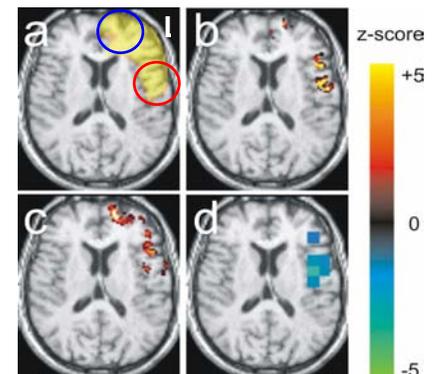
a) left frontal lobe mask (yellow) and pathological regions therein obtained from the b) ADC c) T2, and d) NAA/(Cr+Cho) maps overlaid on a tilted normalized transversal T1-weighted MR image of a TLE patient (male, 56 y).
